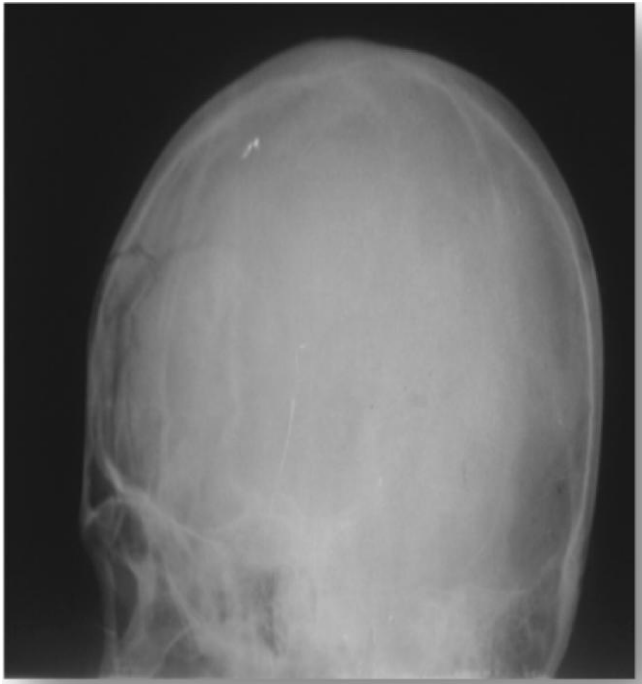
X-Ray Skull showing midline depressed fracture.
